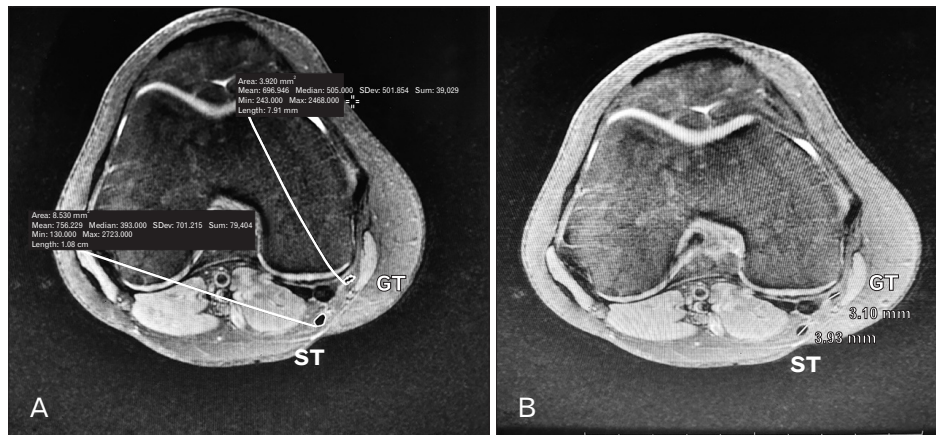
Axial T2 weighted MRI slice at the level of the joint used to calculate the cross-sectional area and the diameter of pes anserinus tendons. The free hand tool of the Osirix software used to measure the CSA of pes anserinus tendons (A). Largest diameter at the chosen slice taken as the diameter of pes anserinus tendons (B). CSA, cross-sectional area; GT, gracilis tendon; MRI, magnetic resonance imaging; ST, semitendinosus.
